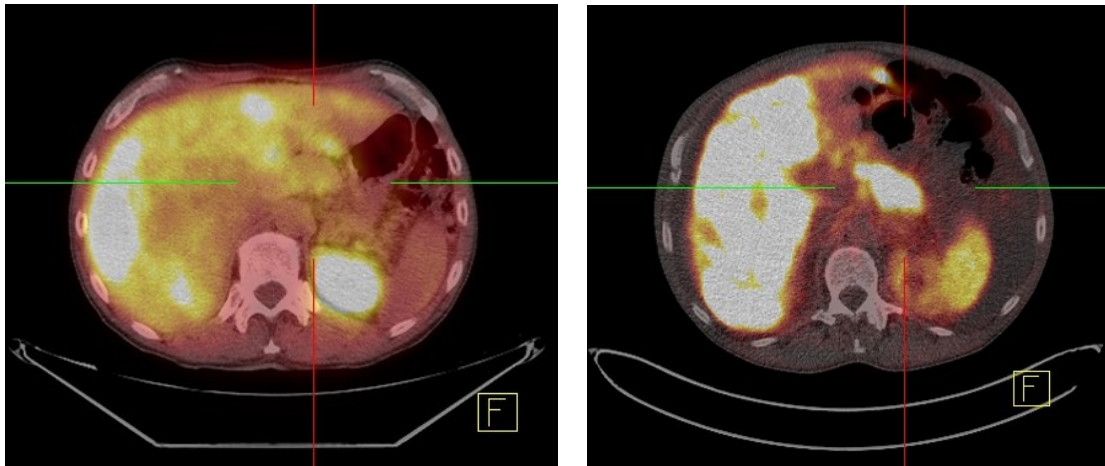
^{18}F -DOPA (left) and ^{68}Ga -DOTA-NOC (right) PET/CT images of the same patient
